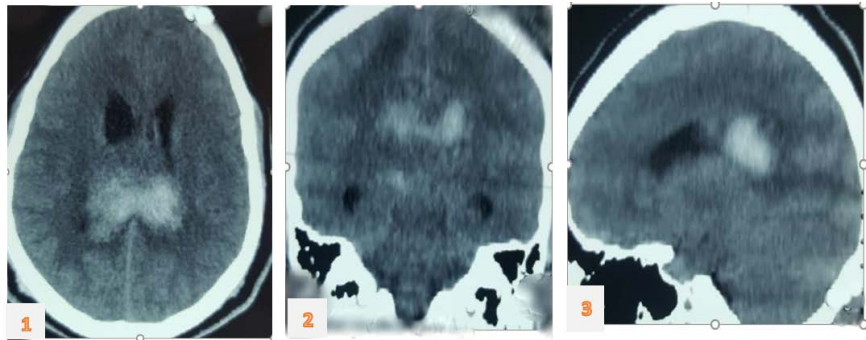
Brain CT without CP injection: spontaneous hyper density at the occipital horns of the lateral ventricles with peri-lesional oedema of the right hemisphere.
